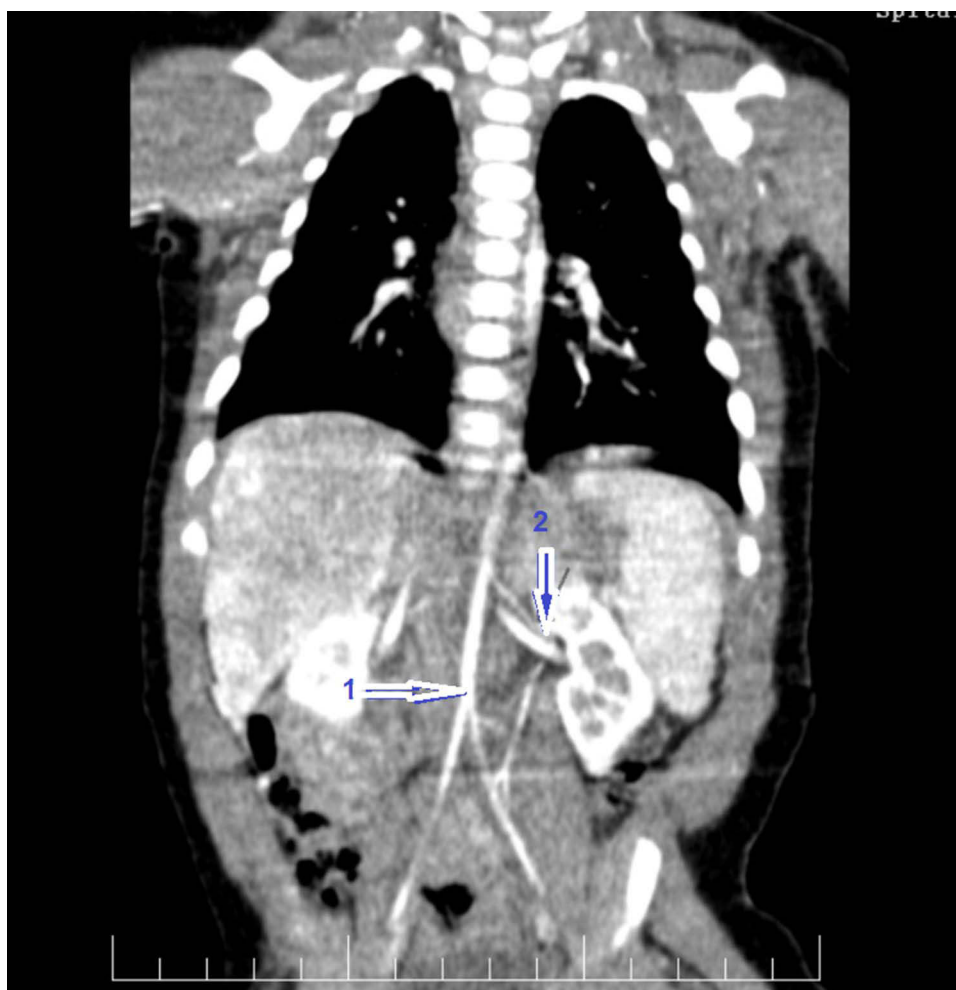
Thoracic and abdominal CT angiogram revealing reduced caliber of the abdominal aorta (Z score -3.8) – (arrow 1) and narrowed left renal artery (diameter $< 1\text{mm}$) – (arrow 2) in a 3-month-old boy with WS.
